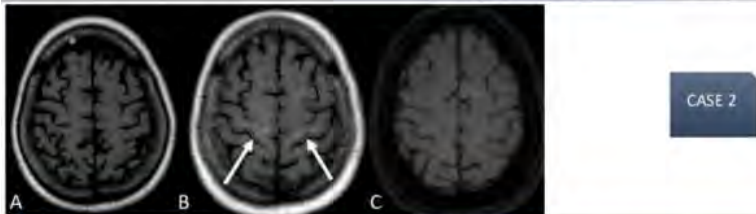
A: Baseline MRI in FLAIR sequence. B: FLAIR sequence on day 154 demonstrates symmetric FLAIR hyper signal intensity in the subcortical motor cortex, arrows. C: Follow-up MRI on day 203 shows interval spontaneous resolution of abnormal signal changes
